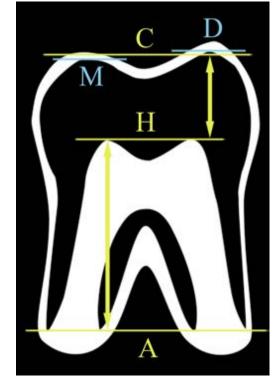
Definition of MR crown height and MR root length on MRI. Lines are perpendicular to the tooth axis. Distances (arrows) are evaluated along the tooth axis.
